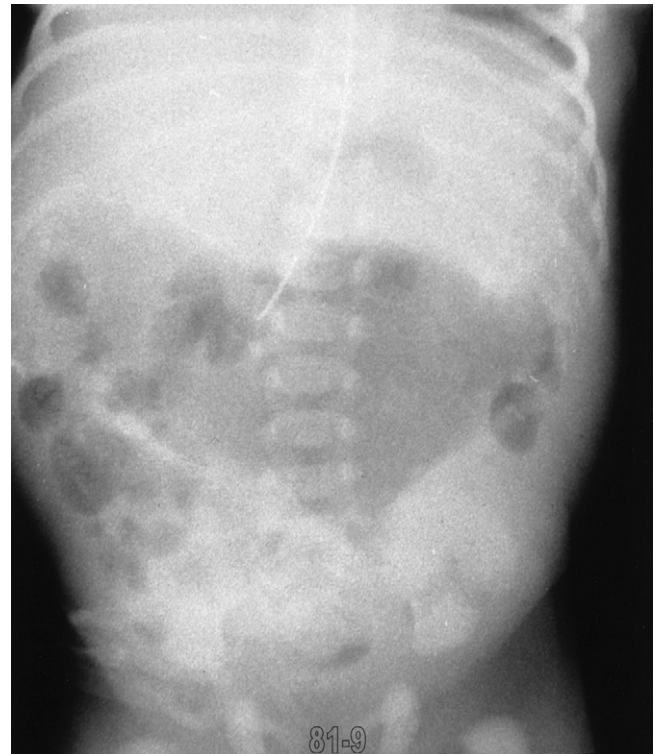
A plain abdominal radiograph compatible with the diagnosis of complicated meconium ileus. The large, central, air-filled mass suggests intestinal perforation and giant meconium cyst formation. If the perforation has been of longer standing, intraperitoneal calcification may also be present. (From Rescorla FJ, Grosfeld JL: Contemporary management of meconium ileus. *World J Surg* 1993;17:381.)
